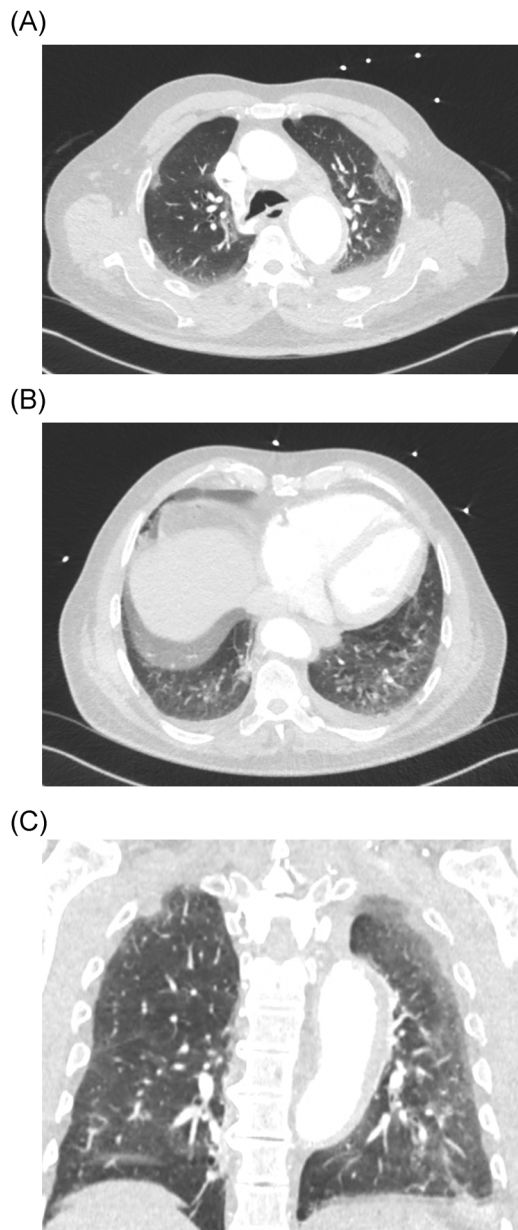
Noncontrasted CT chest—lung windows—in mid-apical (A), lower base apical (B) and coronal views (C), evidencing the presence of acute diffuse ground-glass opacities, compatible with COVID-19 pneumonitis. CT, computed tomography
